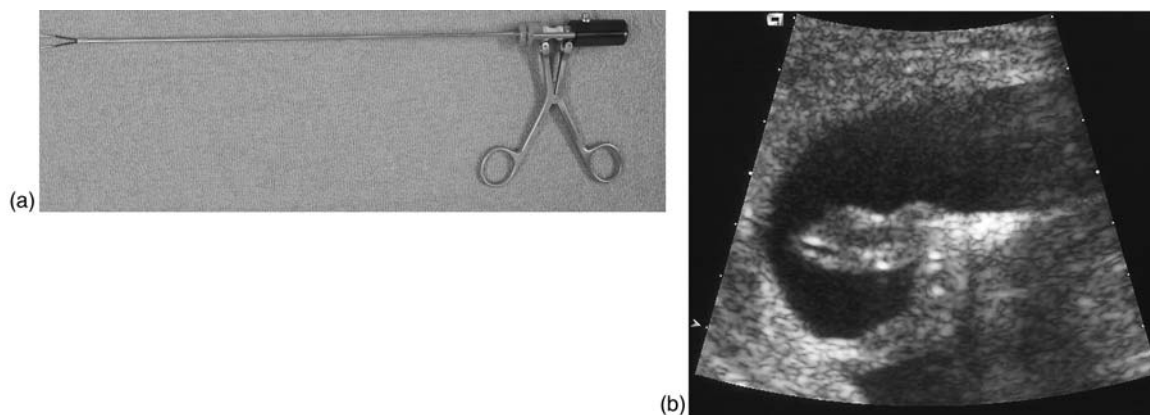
(a) Reusable 2.4-mm bipolar forceps (Karl Storz). (b) Ultrasound image of the bipolar forceps grasping the umbilical cord at its placental insertion.
